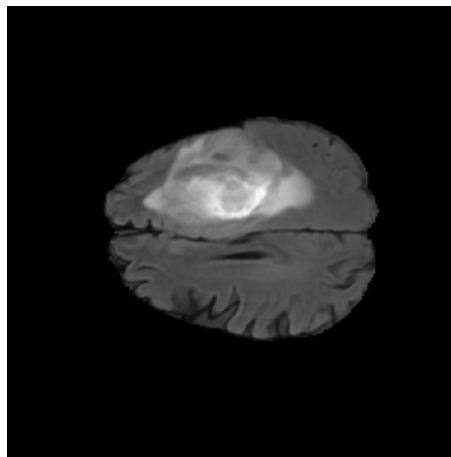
Example of FLAIR MRI sequence.
